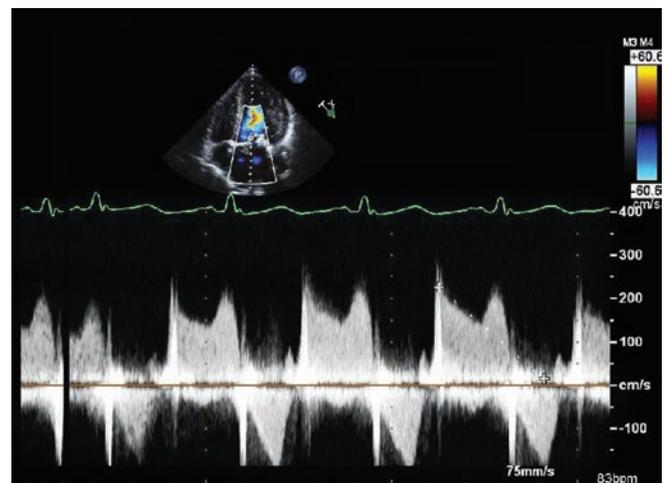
TTE apical four chamber view with tissue Doppler of the mitral valve inflow demonstrating severe function mitral stenosis. Estimated mitral valve area via pressure half time is 1.2 cm², peak mitral inflow velocity 2.3 m/sec and mean pressure gradient 14 mm Hg.
